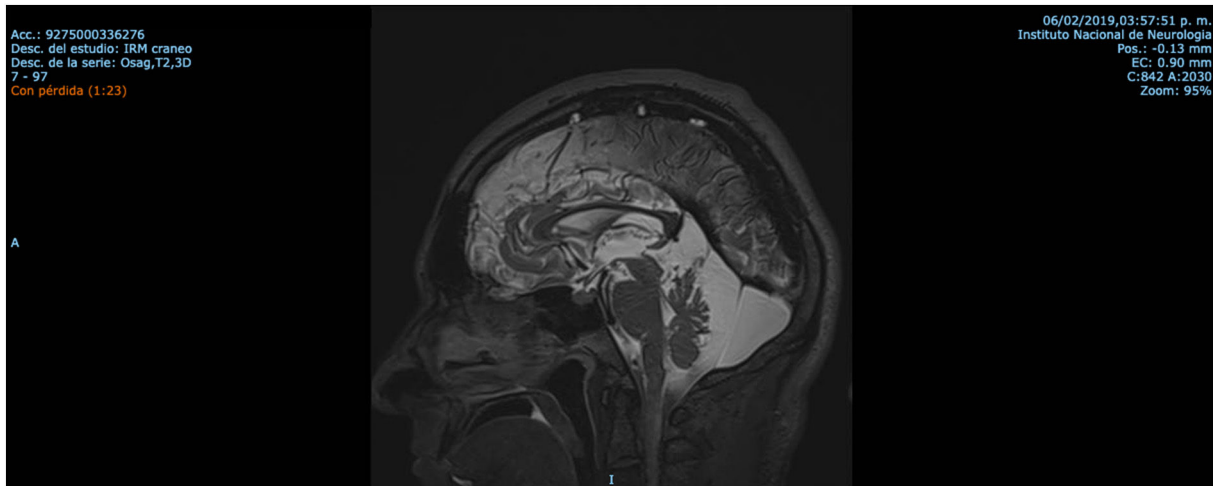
Sagittal T2 MRI. Retrovermian cyst and cerebellar atrophy.
